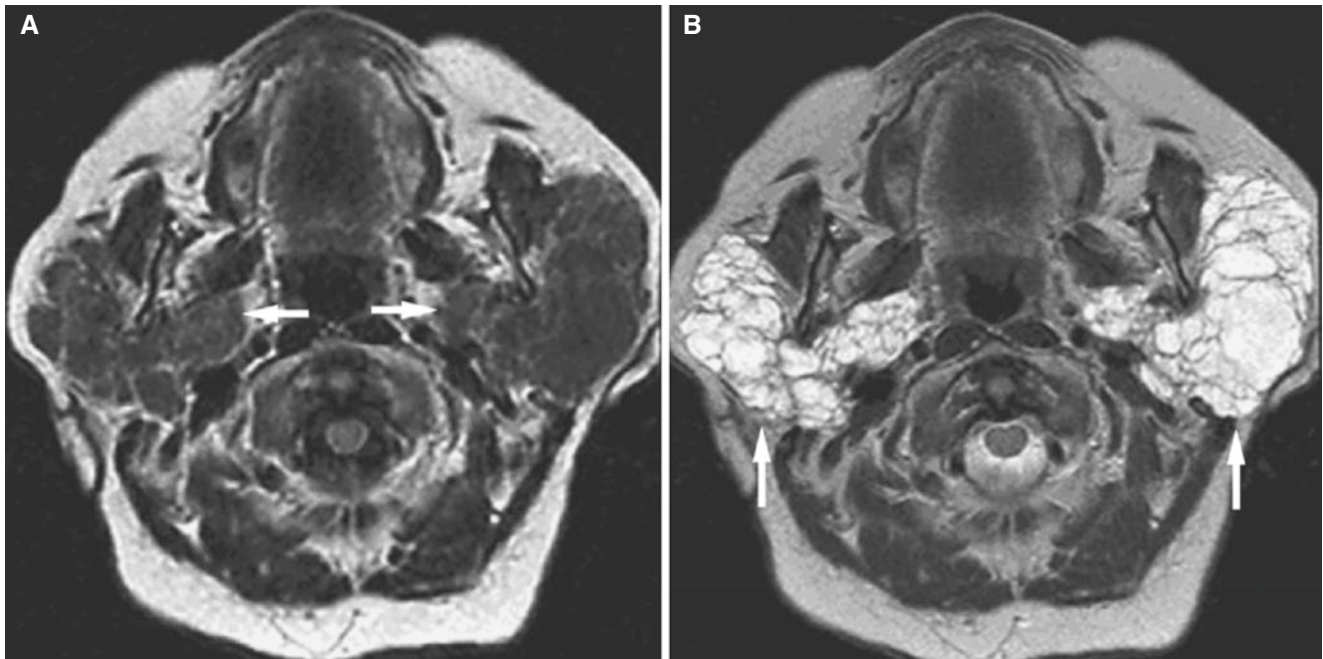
Sjögren's syndrome, advanced stage; 64-year-old female with history of Sjögren's syndrome and multiple sclerosis presents with enlargement of both parotid glands. (A) Axial T1-weighted MRI shows enlarged parotid glands with multiple low-signal cystic changes
